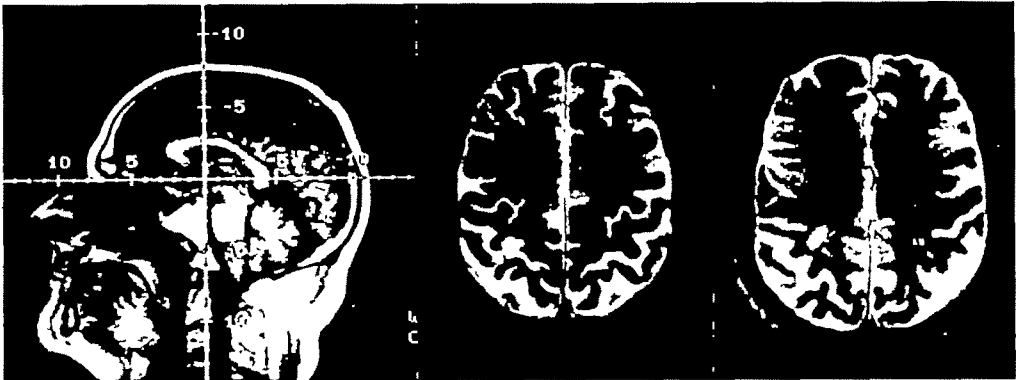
MRI scan 4 mos after O.C.'s stroke, showing small posterior right parietal lesion also seen on second, but not first, CT scan. Centre and right are T_2 weighted axial cuts taken at 3.79 and 2.88 cm above horizontal with centimetre markings seen in T_1 weighted sagittal scout film at left.
